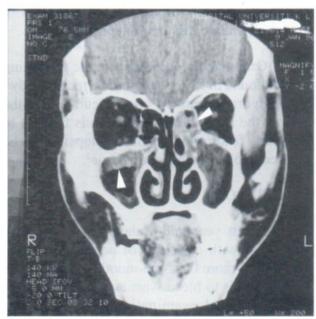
Mucosal thickening of the left ethmoid and right maxillary sinus seen on CT.
